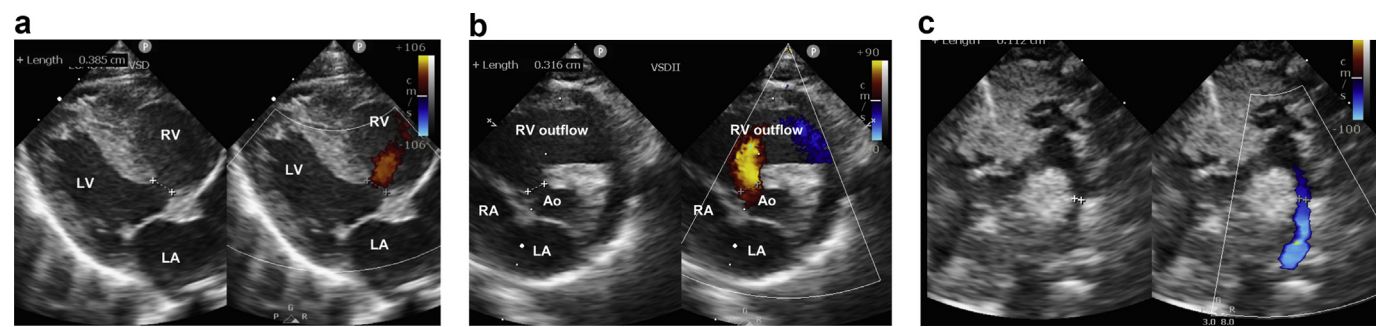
a. Echocardiogram at first day. Parasternal short axis view, Perimembranous type ventricular septal defect. b. Echocardiogram at first day. Parasternal short axis view, Perimembranous type ventricular septal defect. c. Echocardiogram at first day. Suprasternal notch view.
